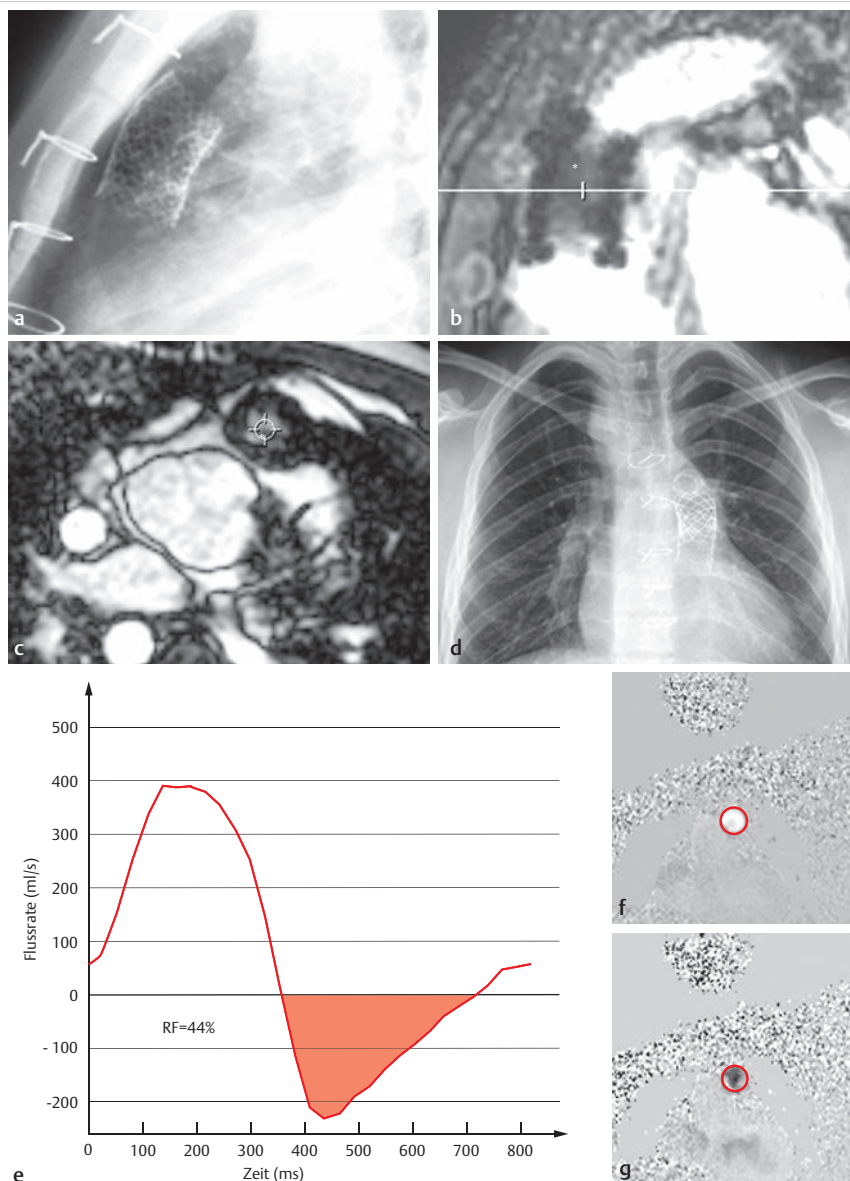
Condition after stent implantation near a homograft stenosis, after surgical correction of common arterial trunk and multiple reoperations due to homograft stenosis. This is the same patient as in ► Fig. 4.99. Even in the MR SSFP cine sequence (b, c), the stent lumen is partially visible under certain circumstances (e.g., nitinol stents). The tricuspid trunk valve (neo-aortic valve) is also visible in transverse slices (c). Depiction of flow curves (e) and phase images (f, g) in MRI flow measurement cranial to the implanted stent in the pulmonary arterial conduit, perpendicular to the main direction of flow (through-plane). After stent implantation in the homograft, pronounced pulmonary insufficiency (holodiastolic regurgitation) in the phase image during diastole (g; caudal flow depicted in black) and in the flow curve (e) with a measured regurgitation fraction of 44% of antegrade flow (pale red area) can be revealed.
